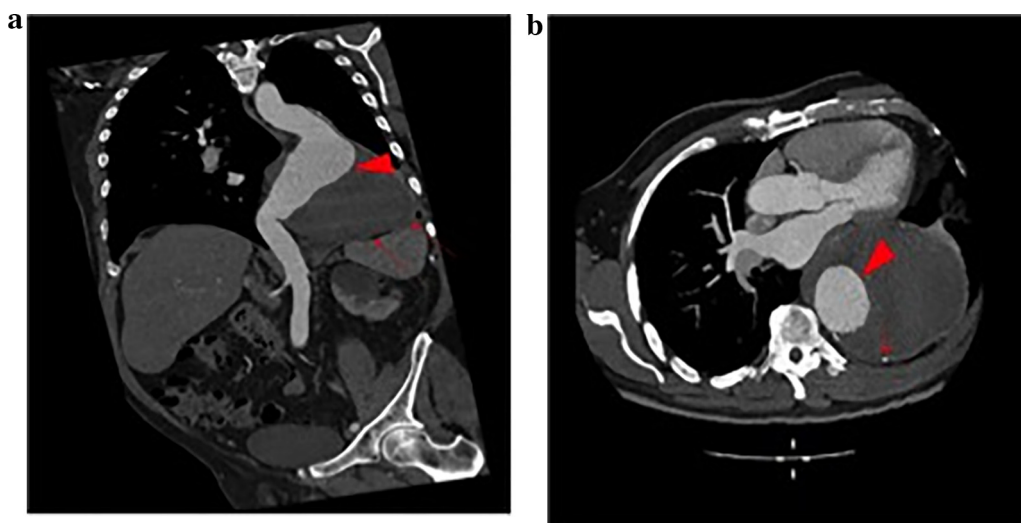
a) Coronal MPR CT image obtained with intravenous contrast in arterial phase shows a sacular aneurysm of the descending aorta, with the presence of an intramural thrombus (arrows). There is no extravasation of the contrast media from the true lumen (arrowhead). b) Axial MPR image shows calcification of the aortic wall (arrowhead). The true lumen (arrowhead) measures 7.4 cm; the aneurysm measured in the perpendicular plane has a diameter of 15.6 cm.
